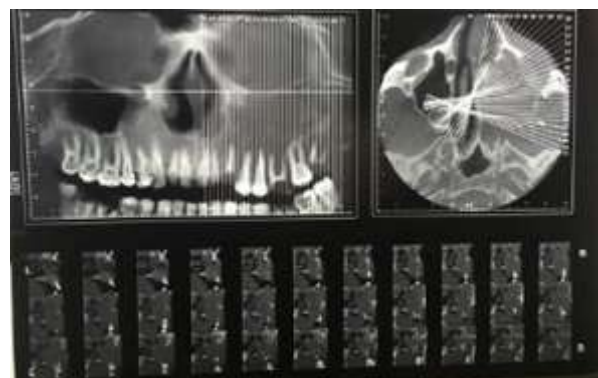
CBCT showing an unidentified radiolucent lesion from the left maxillary first molar to the tuberosity and from the crest apex to the orbit floor
